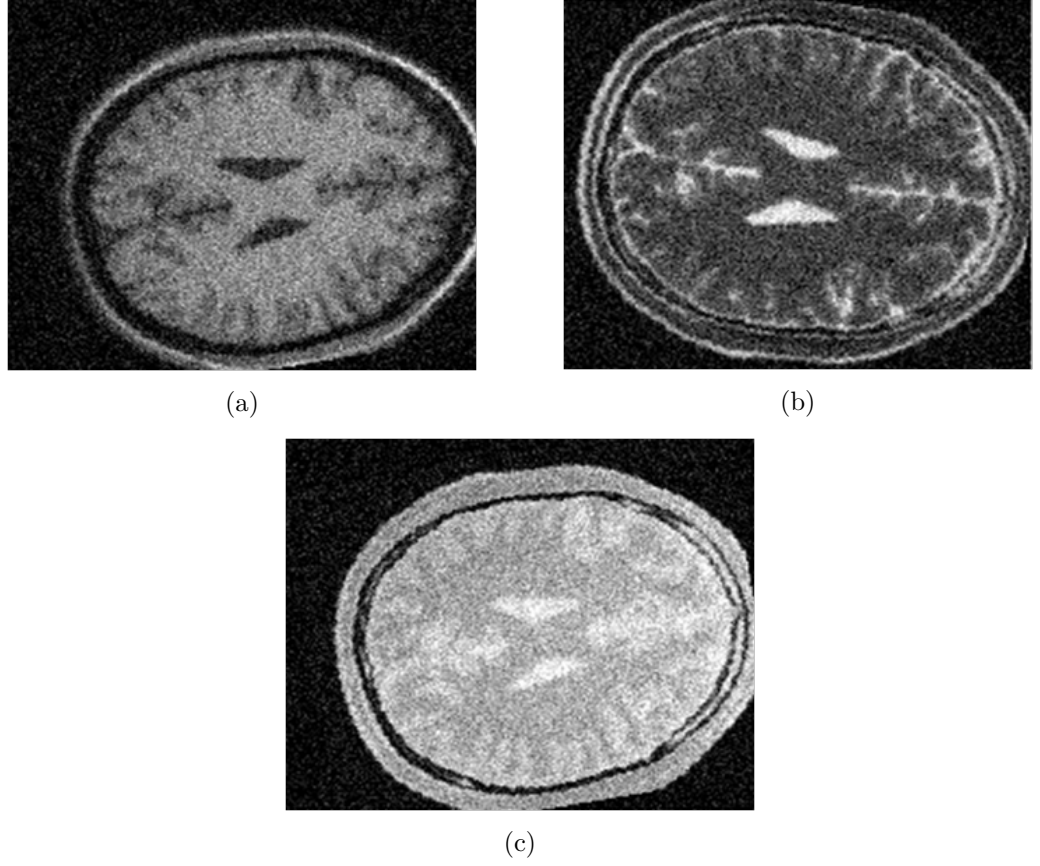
Example *BrainWeb* images of misregistered brain MRI (a) $T1+\alpha_{40}+\beta$, (b) $T2+\alpha_{40}+\beta$ and (c) $PD+\alpha_{40}+\beta$ from (Montreal Neurological Institute and Hospital, nd).
